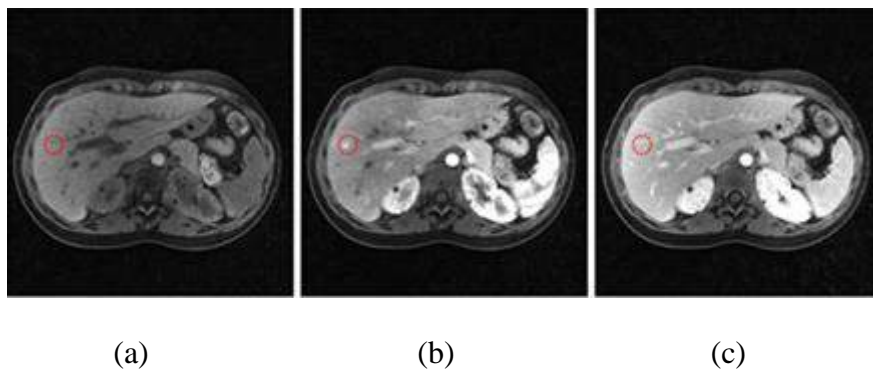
DCE MRI liver phases. Representing a) pre-contrast b) arterial and c) post contrast.
